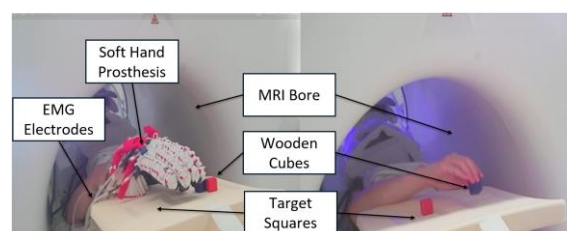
Pick-and-place task with the EMG-controlled MRI compatible prosthesis and own hands.
